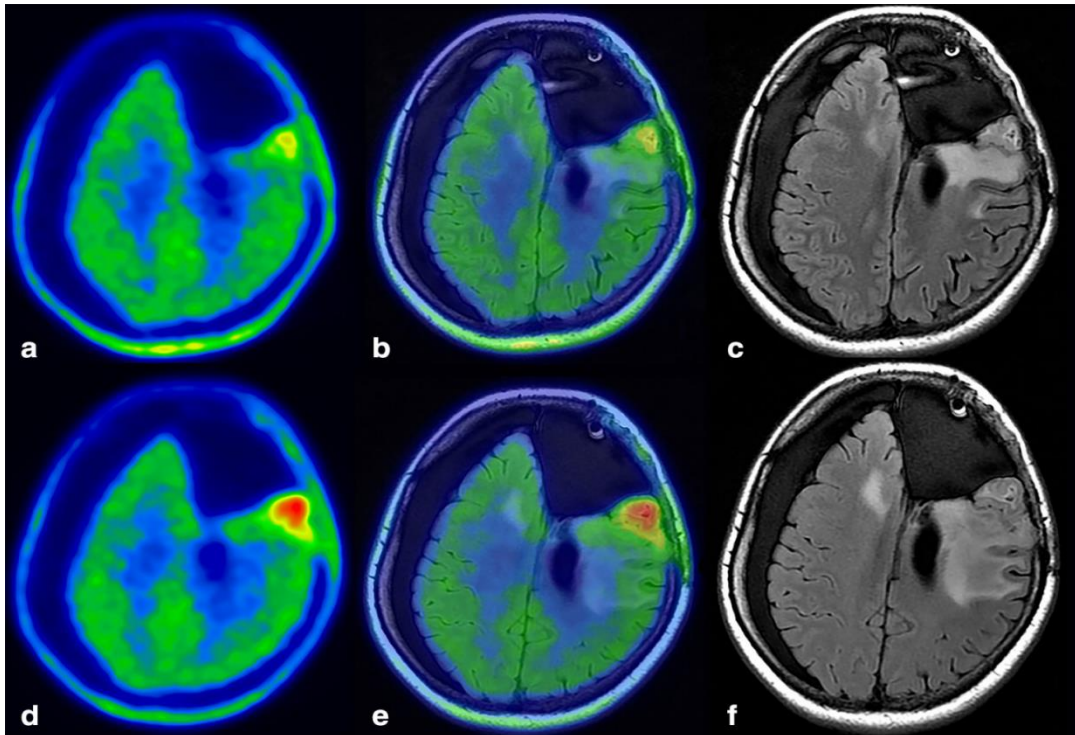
a Axial cross-section showing increased [^{18}F] FDOPA uptake in the rest of the frontal lobe after surgery in a Grade III glioma patient ($\text{SUVr} = 1.45$) 6 months after surgery. In b, we report on PET / MRI fusion imaging, and in c, we report on T2-emphasized MRI. A 13-month follow-up of d shows disease progression with a further increase in [^{18}F] FDOPA uptake ($\text{SUVr} = 1.7$). e reports on PET / MRI fusion imaging, and f reports on T2-emphasized MRI.
